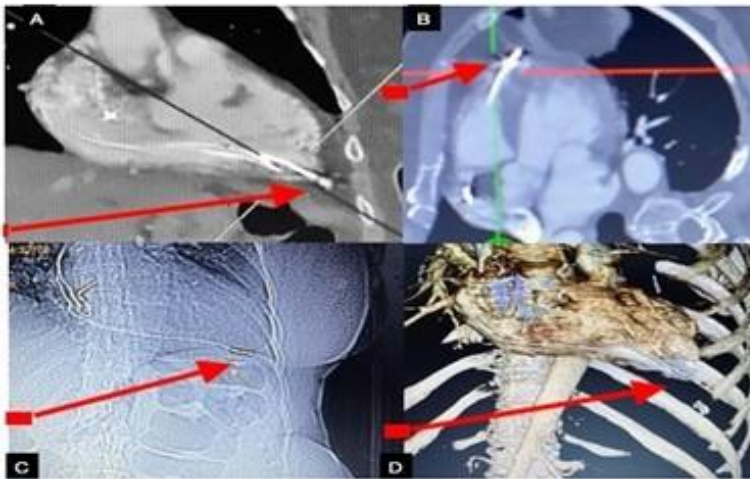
CT images showing RV lead perforating the RV apex into the pericardium. (a) Coronal plane showing RV lead perforating and crossing the RV apex. (b) Axial plane showing the heart in four-chamber view with RV lead perforating the apex. (c) Another coronal plane showing RV lead perforation. (d) 3D coronal plane also showing the RV lead extending past the RV wall.
